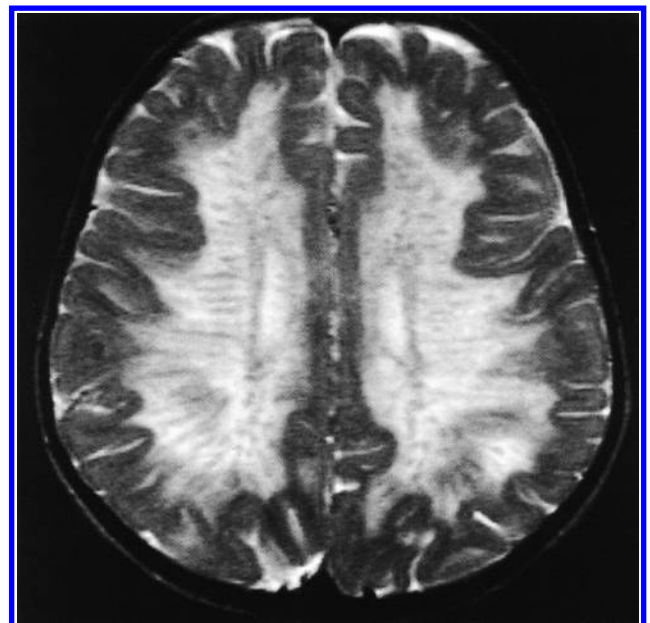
Magnetic resonance image of the brain of a five-year-old female with metachromatic leukodystrophy. There was diffuse high T_2 signal throughout the white matter in a sunray appearance. She had regressed developmentally and had diminished deep tendon reflexes.
